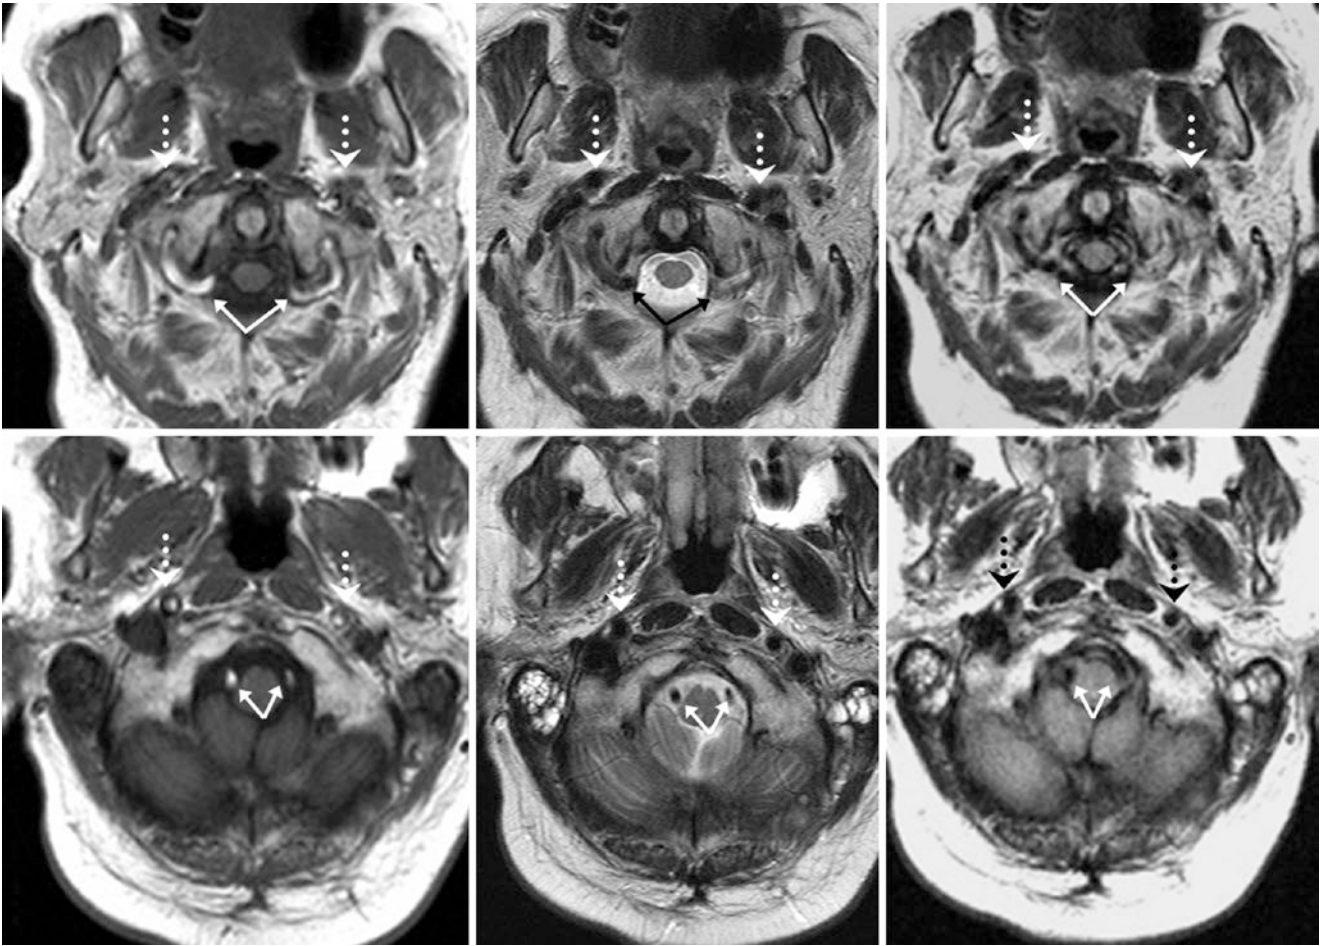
In this 62-year-old, bright signal was noted within both vertebral arteries (VAs) (*solid arrows*) just below the skull base on noncontrast T1WI (*top left* and *bottom left*). However, both VAs are patent with flow voids on T2WI (*top middle* and *bottom middle*) and FLAIR (*top right* and *bottom right*). Similarly, on noncontrast T1WI, bright signal is seen in both internal carotid arteries (ICAs) (*large dotted arrows, best seen on bottom left*), but with patent flow voids in those locations on both T2WI and FLAIR images
